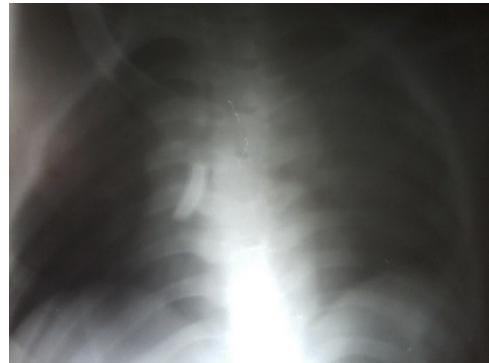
A radiopaque shadow in the area of the right bronchus. The Xray film taken is not of a good quality due to inability to hold the patient in a steady position.
